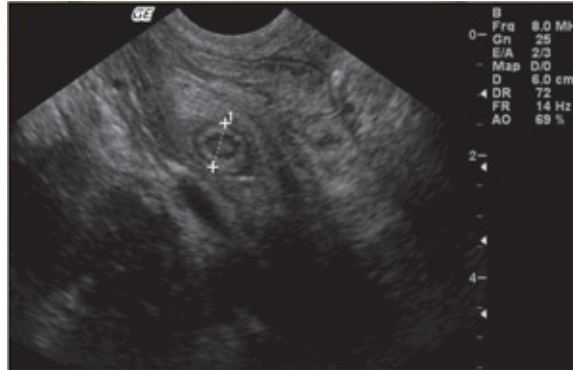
Ultrasound image displaying acute appendicitis.
